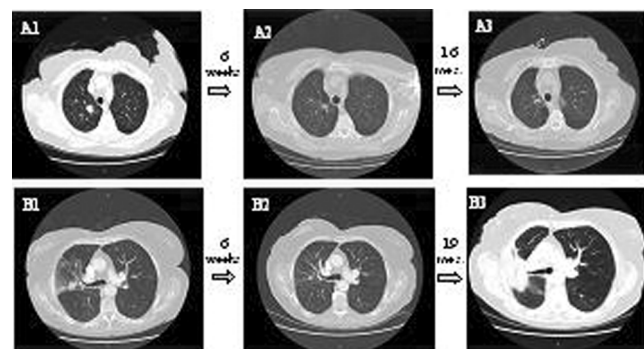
(A1-A3) Serial CT scan of a patient with a complete radiographic and PET response. (B1-B3) Serial CT scan of a patient with an initial complete radiographic response and subsequent development of likely post-radiation changes.
